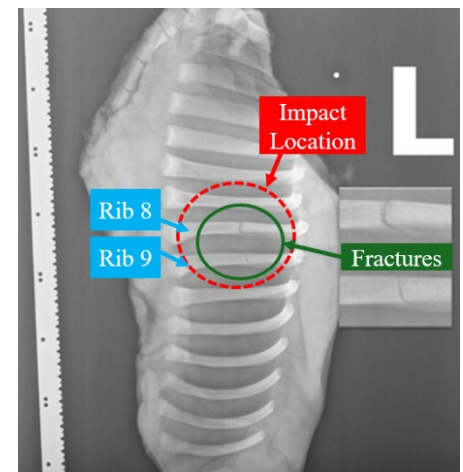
A: an example of the multilateration results of the initial fracture location. Pink Triangle represents the fracture located at $(-0.0373, -0.00412)$ from the centre of impact $(0,0)$, represented by the Green Diamond. Orange Circles represent the hydrophone sensor locations. The localised initial fracture was on rib nine, near the centre of impact. B: x-ray confirming a transverse fracture on rib eight and a hairline on rib nine. The red chequered circle represents the location of the impact.
